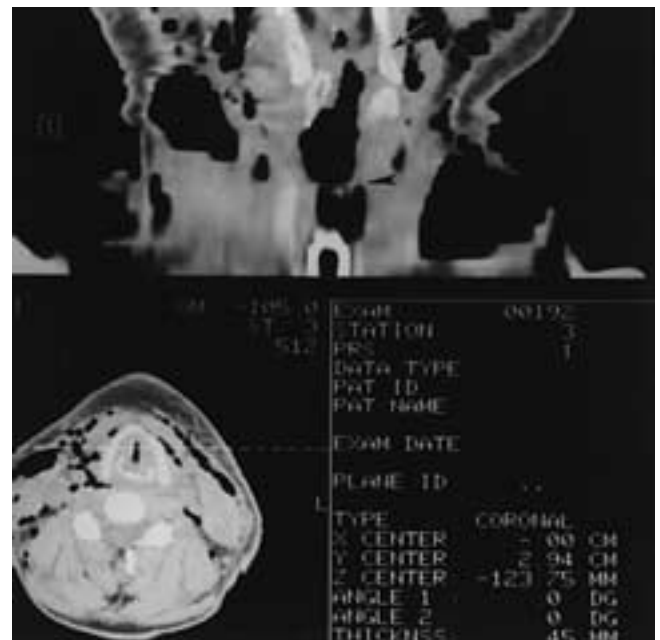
Coronal reformat of a horizontal fracture of the thyroid cartilage (arrow) and laryngotracheal partial separation. Note the lack of alignment of the trachea (arrowhead). This finding can be mimicked on reformatted CT slices by movement of the patient during the exam.
